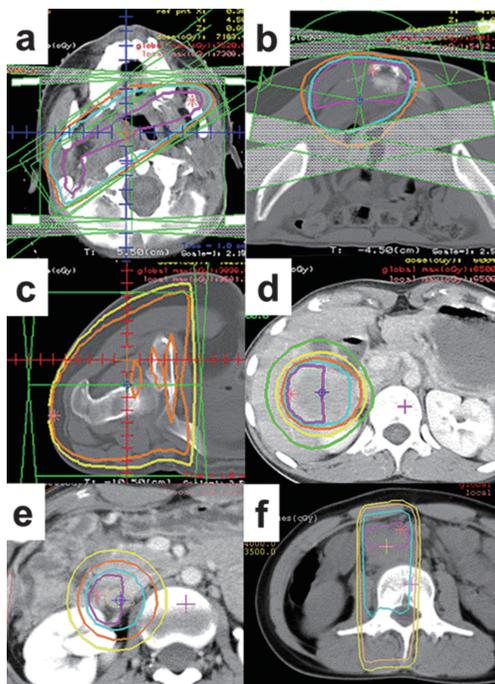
CT images with radiation dose distribution
